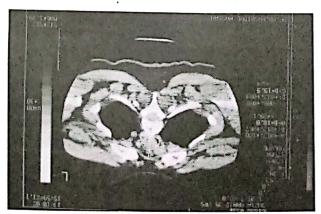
HRCT scan of chest
